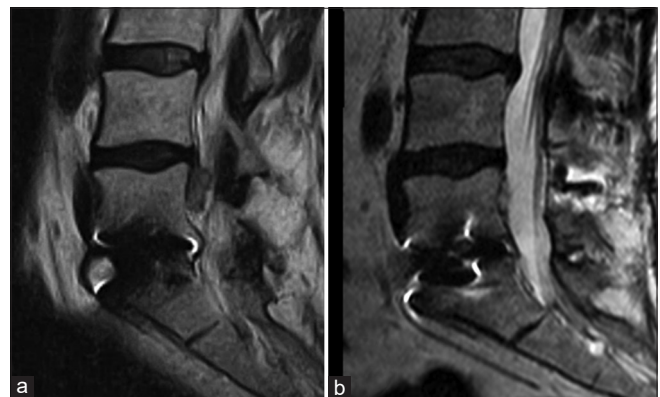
(a) Preoperative and (b) postoperative T2-weighted magnetic resonance imaging showing resolution of the epidural venous plexus after surgical intervention, confirming its etiology as the source of radiculopathy.
